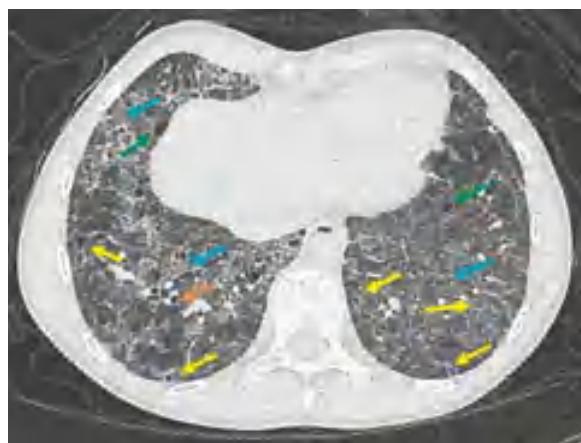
Chest CT demonstrates typical CT findings in a pediatric patient with nonspecific interstitial pneumonia, including basilar-predominant ground-glass opacities (blue arrows), reticulation (yellow arrows), mild cystic change (green arrows), and bronchiectasis (orange arrow).
